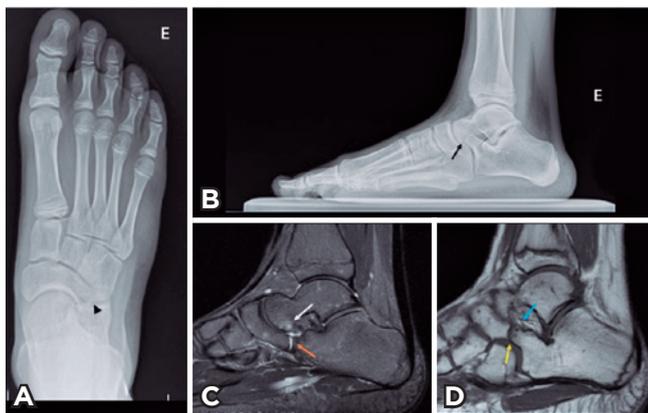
A. AP x-ray showing reverse anteatler nose sign (arrow head). B. Weighted lateral x-ray: Elongated anterior process of the calcaneus (black arrow). Magnetic resonance imaging. C. Sagittal T2 section. Plantar elongation of the navicular in contact with the head of the talus; moreover, osseous edema and fluid between the talus and the coalition was observed (white arrow). Fibrocartilaginous coalition between the calcaneus and the navicular (orange arrow). D. Sagittal T1 section. Elongation of the navicular bone creating an abnormal joint with the cuboid bone. (yellow arrow), cysts in the anterior portion of the calcaneus in contact with the navicular (blue arrow).
